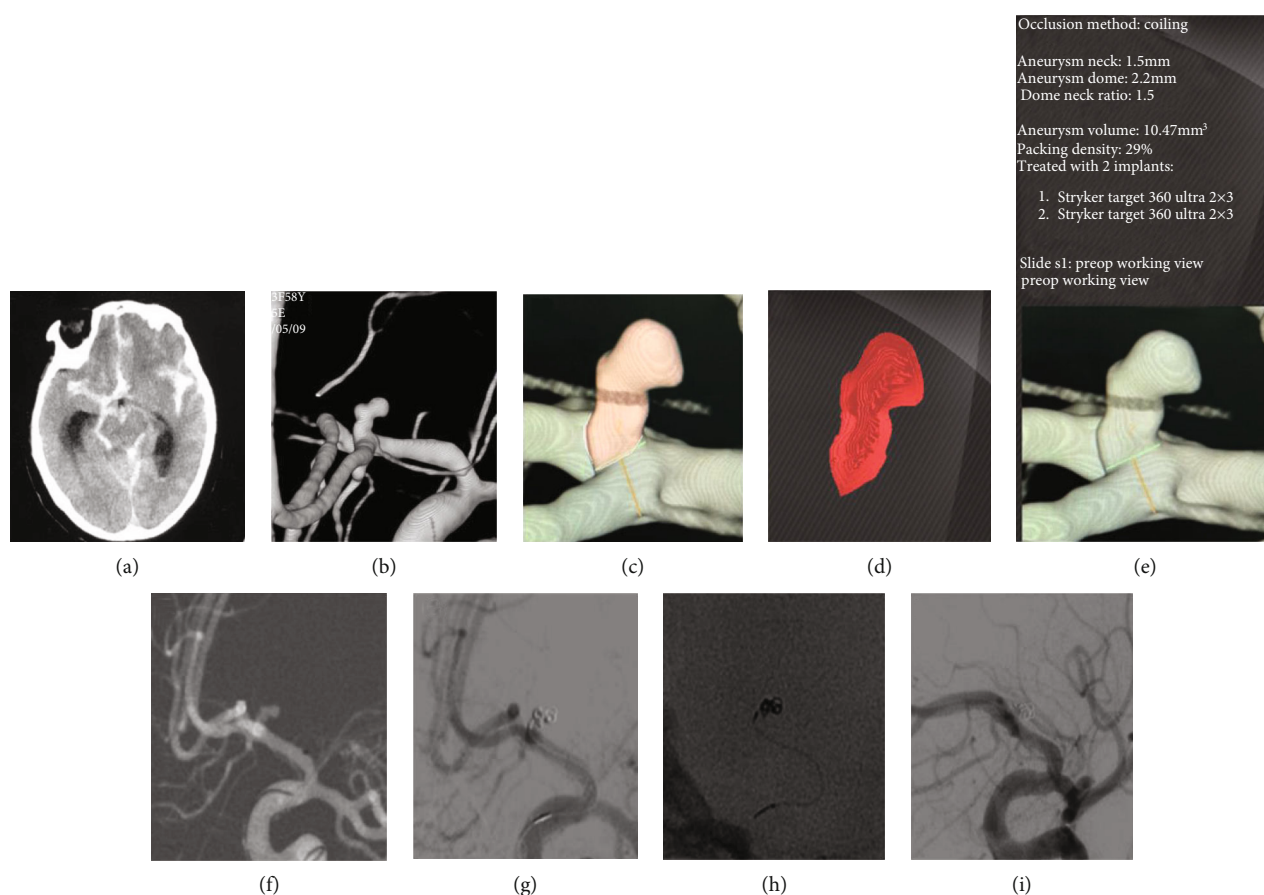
Case presentation of patient 6, female, 58 years old. She presented with (a) SAH on noncontrast head CT and (b) a ruptured irregular AcoA aneurysm on 3D reconstruction image of DSA. The AngioSuite software was used to configure and evaluate the volume of aneurysm before the embolization procedure (c–e). Based on the AngioSuite data, embolization with 2 coils (two targets 2–3 mm) could achieve sufficient immediate occlusion (Raymond 2) (f, g). Sparse coils showed on nonsubtracted image (h). Six-month follow-up showed a complete occlusion (Raymond 1) (i).
